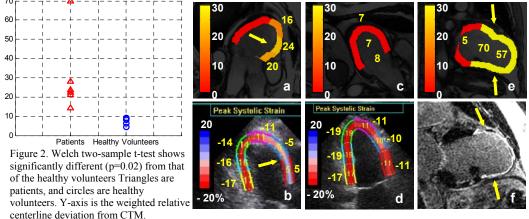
Centerline trajectory mapping is shown on a patient (a) with anteroseptal myocardial infarction and focal hypokenisis. Corresponding echocardiography strain map (b) in 3chamber view shows decreased strain in the same region (5 vs. 16 and 17 in the inferolateral wall). CTM on a healthy subject 2-chamber MR (c) is compared with echo strain map (d) which shows normal wall motion. The global wall motion abnormality CTM (e) is consistent with finds of apical aneurysm of the left ventricle with hyperenhancement pattern on myocardial delayed enhancement. imaging (arrows in f). Red = normal, orange = focal wall motion abnormality, and yellow = global wall motion abnormality.
